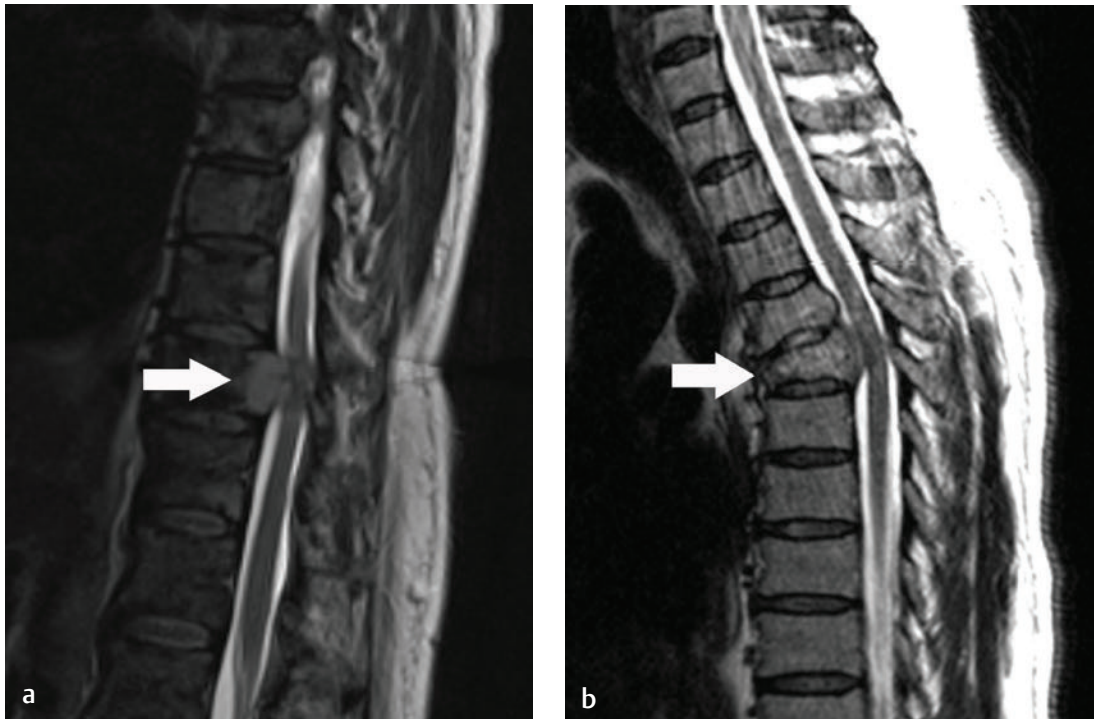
Sagittal T2-weighted images of extradural metastatic lesions reveal compression and distortion of the underlying dura and spinal cord in two different patients. (a) Prostate metastasis (*arrow*) to the thoracic spine with epidural extension. (b) Non-small-cell lung cancer metastasis to the upper thoracic spine with epidural extension. Loss of vertebral body height is noted (*arrow*).
